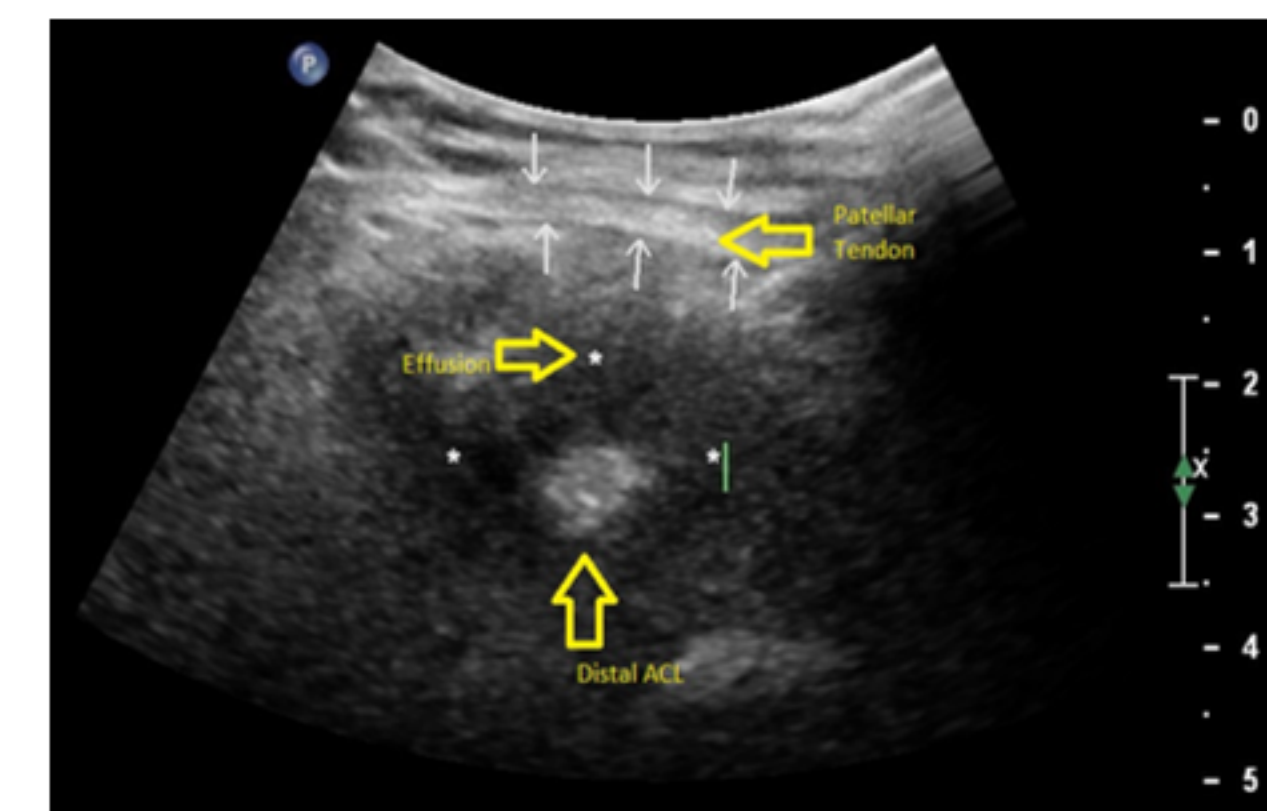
C5-1 MHz curvilinear ultrasound short axis view of patellar tendon, synovial fluid and distal ACL.
